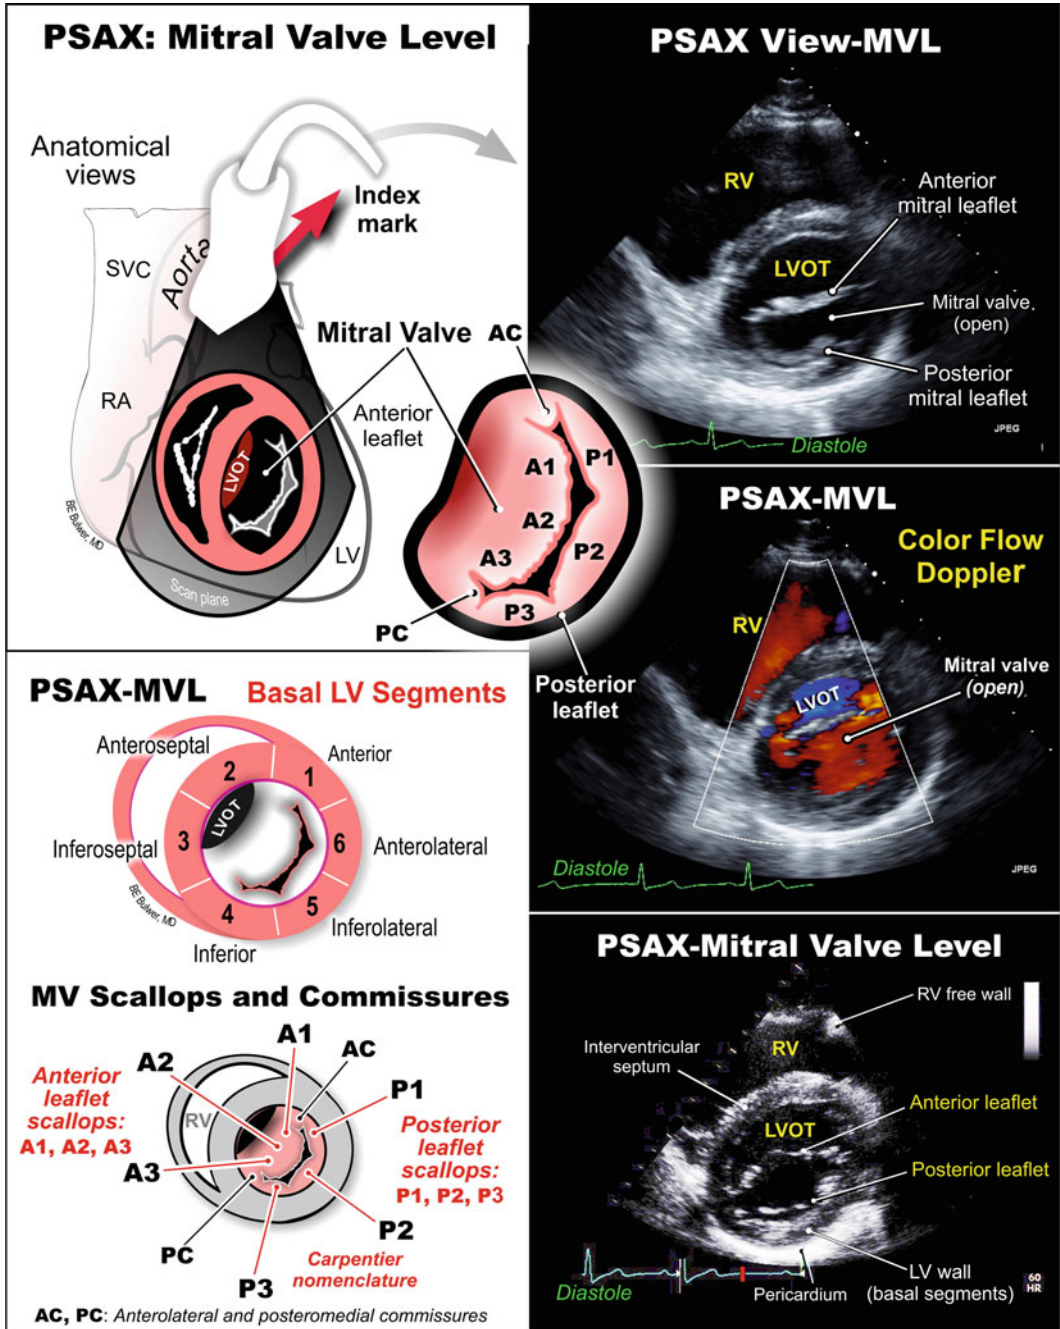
PSAX-Mitral Valve Level: Scan Plane Anatomy. Parasternal short axis view—mitral valve level (PSAX-MVL) on transthoracic echocardiography (TTE).
